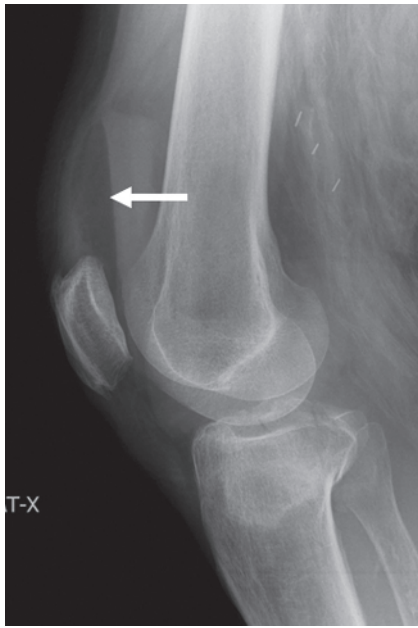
Lipohemarthrosis. Cross-table lateral radiograph shows a fat-fluid level (arrow) in the suprapatellar pouch. Sclerosis in the proximal tibia is related to a depressed tibial plateau fracture.
